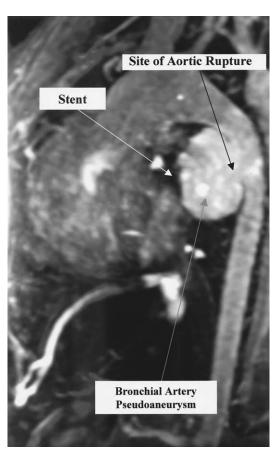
Contrast magnetic resonance imaging of patient 2 demonstrating the bronchial artery pseudoaneurysm and site of mycotic descending aorta rupture.
